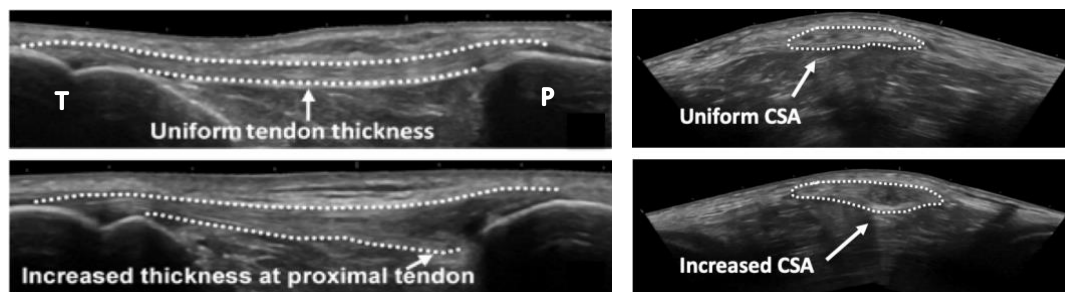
Ultrasound imaging for uninjured (top) and injured (bottom) patellar tendons. Long-axis images are displayed on the left, and short-axis images are displayed on the right. The inferior pole of the patella (P) and tibial tuberosity of the tibia (T) are shown in long-axis view for the uninjured tendon.
